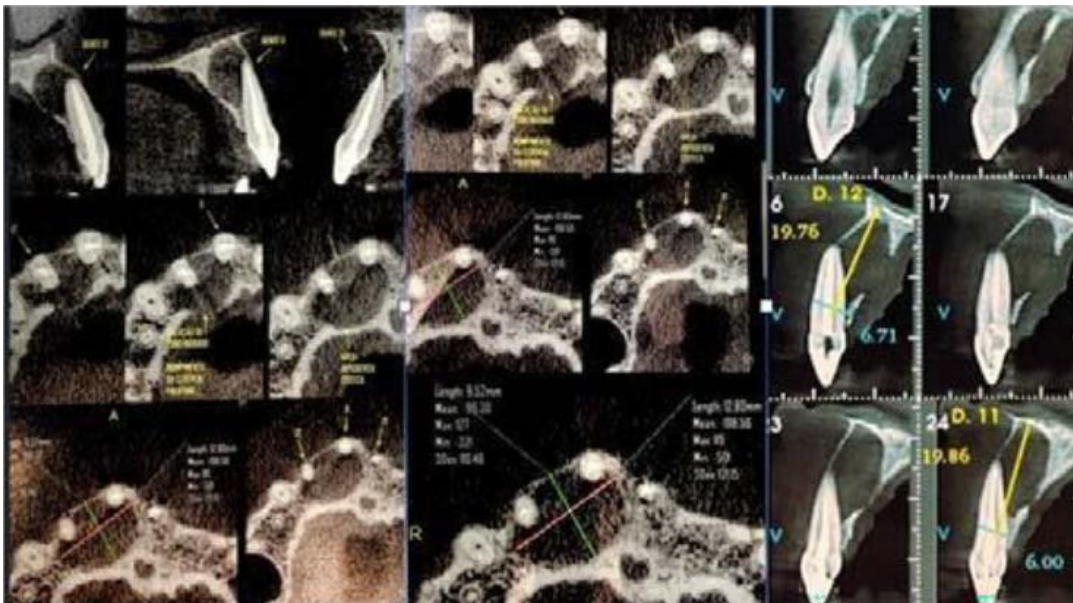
CT image showing the extension, depth, length of the cystic lesion between teeth 1.1,1.2,1.3.
